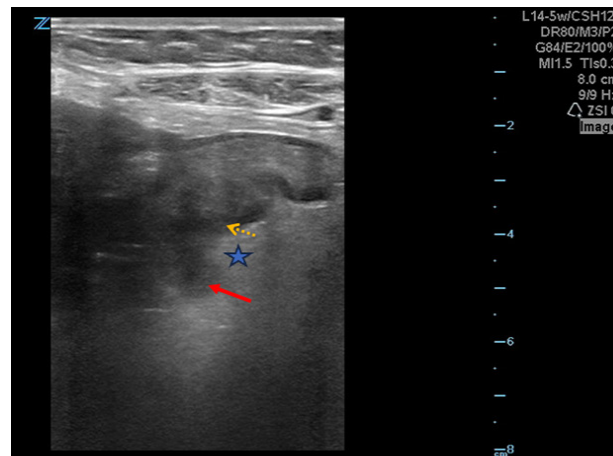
Ultrasound image obtained using a linear probe showing hyperechoic pericolic fat (star) surrounding a diverticulum (red arrow) with colonic wall thickening (dotted yellow arrow) with higher resolution
